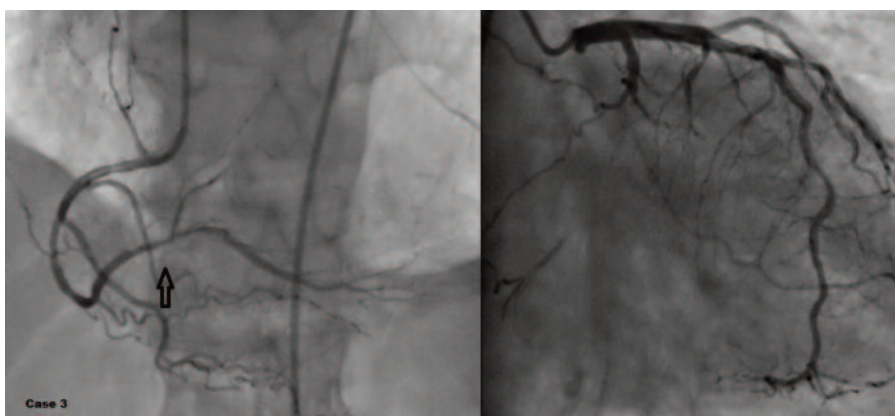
A 61-year-old female patient was admitted to our hospital with complaints of typical chest pain and dyspnea for 20 days. She had history of hypertension, diabetes mellitus, chronic obstructive pulmonary disease, and myocardial infarction. Stress echocardiography revealed biphasic response to accelerated dobutamine doses suggesting viability. Coronary angiography revealed total occlusion of the CX and intermediate stenosis at the RCA (arrow) with Rentrop grade-3 collateral flow to the CX. Initial and final FFR values were 0.62 and 0.72, respectively.
